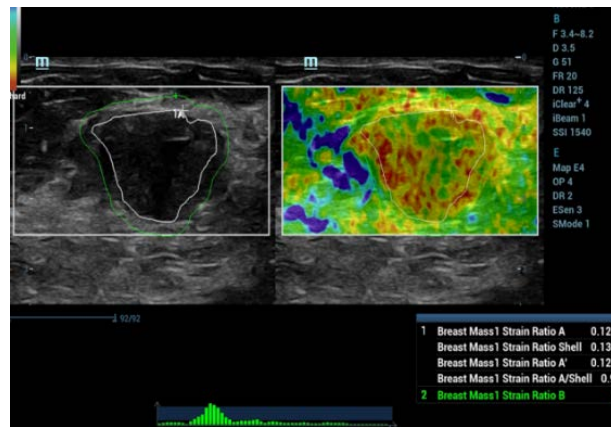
Ultrasound elastography of malignant breast mass, BIRADS = 5, with scoring value = 0.9 SR
